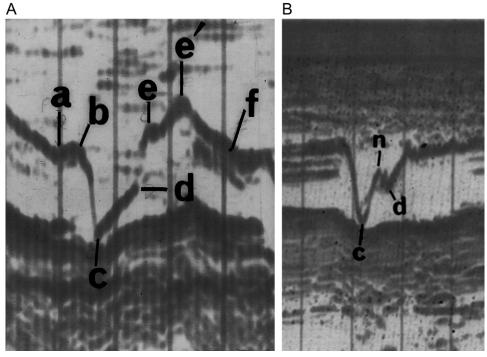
A, M-mode examination of a normal pulmonic valve. Only 1 of the leaflets is usually recorded. B, M-mode pulmonic valve recording from a patient with pulmonary hypertension. The "a" wave is absent, and there is mid-systolic closure (n) in mid-systole. This finding has been called the "flying W" sign. (From Feigenbaum H. Echocardiography. 1st ed. Philadelphia, PA: Lea and Febiger; 1972.)
